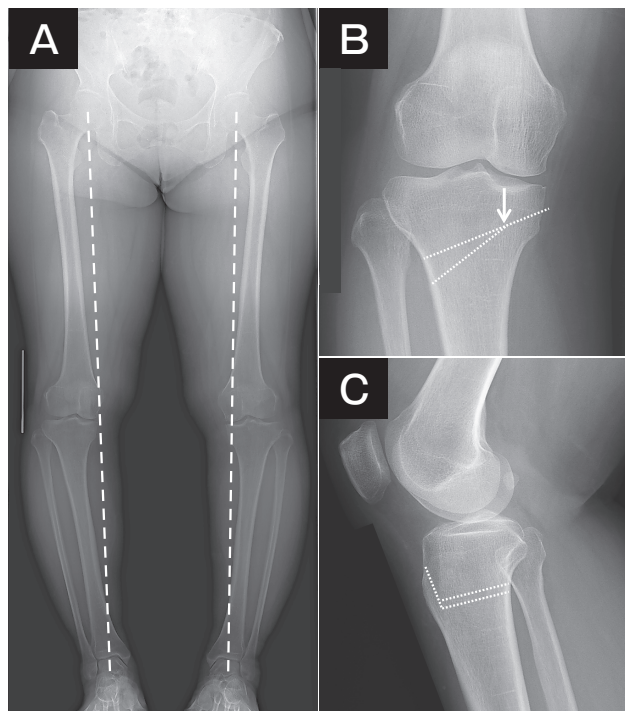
Radiographic images of a 58-year-old woman. (A) Standing AP view. (B) Dotted lines indicate osteotomy lines. Hinge point (arrow). (C) Lateral view.
